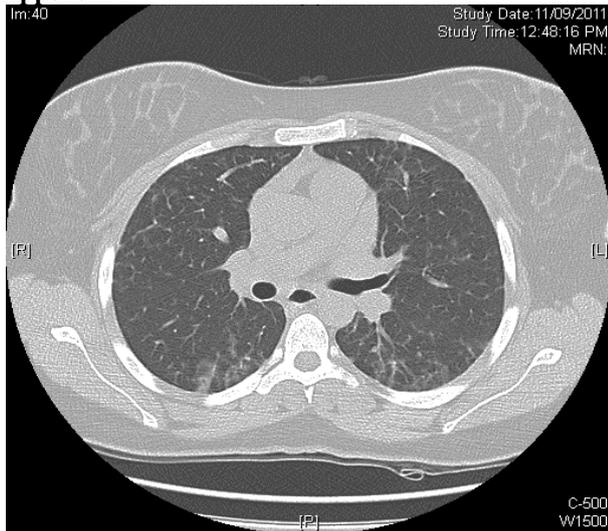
High resolution CT Chest Sept 2011 showing bilateral fibrosis mainly lower lobes.
